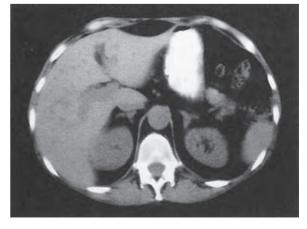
CT scan of the abdomen showing bilateral enlarged hyperplastic adrenal glands in the ectopic adrenocorticotrophic hormone syndrome.
